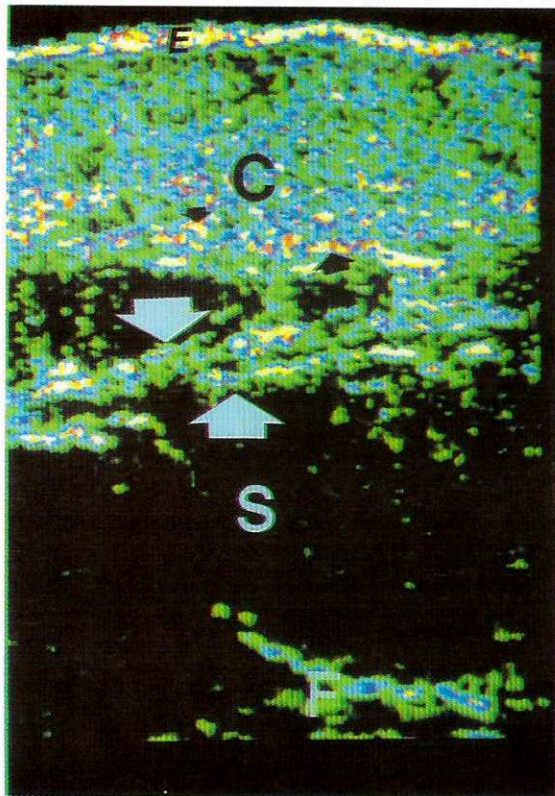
Ultrasound B-scan of diseased skin on the right flank (Case Study 1) (E: entry echo; C: corium; S: subcutaneous fatty tissue; F: muscle fascia; black arrow: enhanced reflexes; white arrows: echorich bands).
